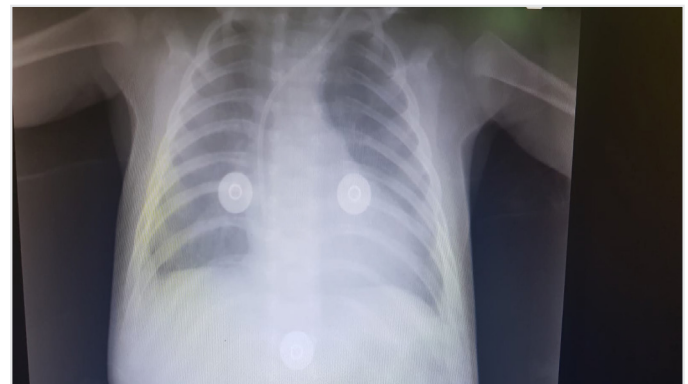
On the 10th day of hospitalization chest X-ray shows improved cardiomegaly and bilateral diffuse opacities
